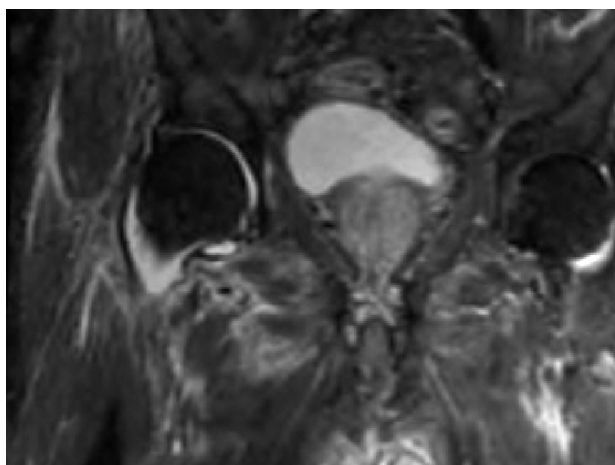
MRI showing joint effusion and inflammation.
